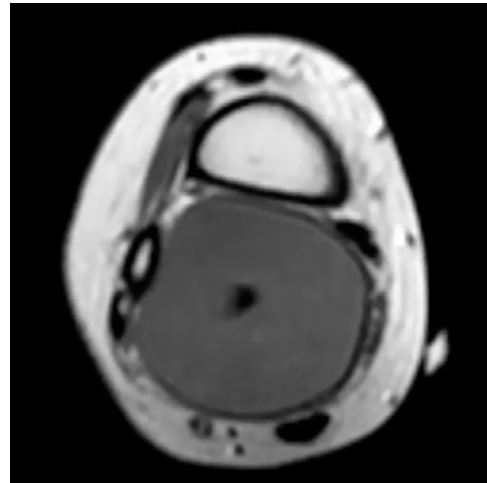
Axial T1 magnetic resonance imaging cut demonstrating a T1 hypointense cystic lesion with the flexor hallucis longus coursing through the cystic area.
